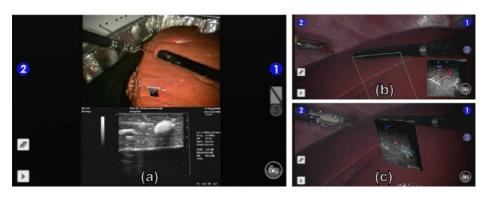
(a) A split-screen display that shows the endoscopic view and the ultrasound image adjacent to one another in the surgical console. (b) A picture-in-picture view of the ultrasound image. (c) The ultrasound "flashlight" overlay.
